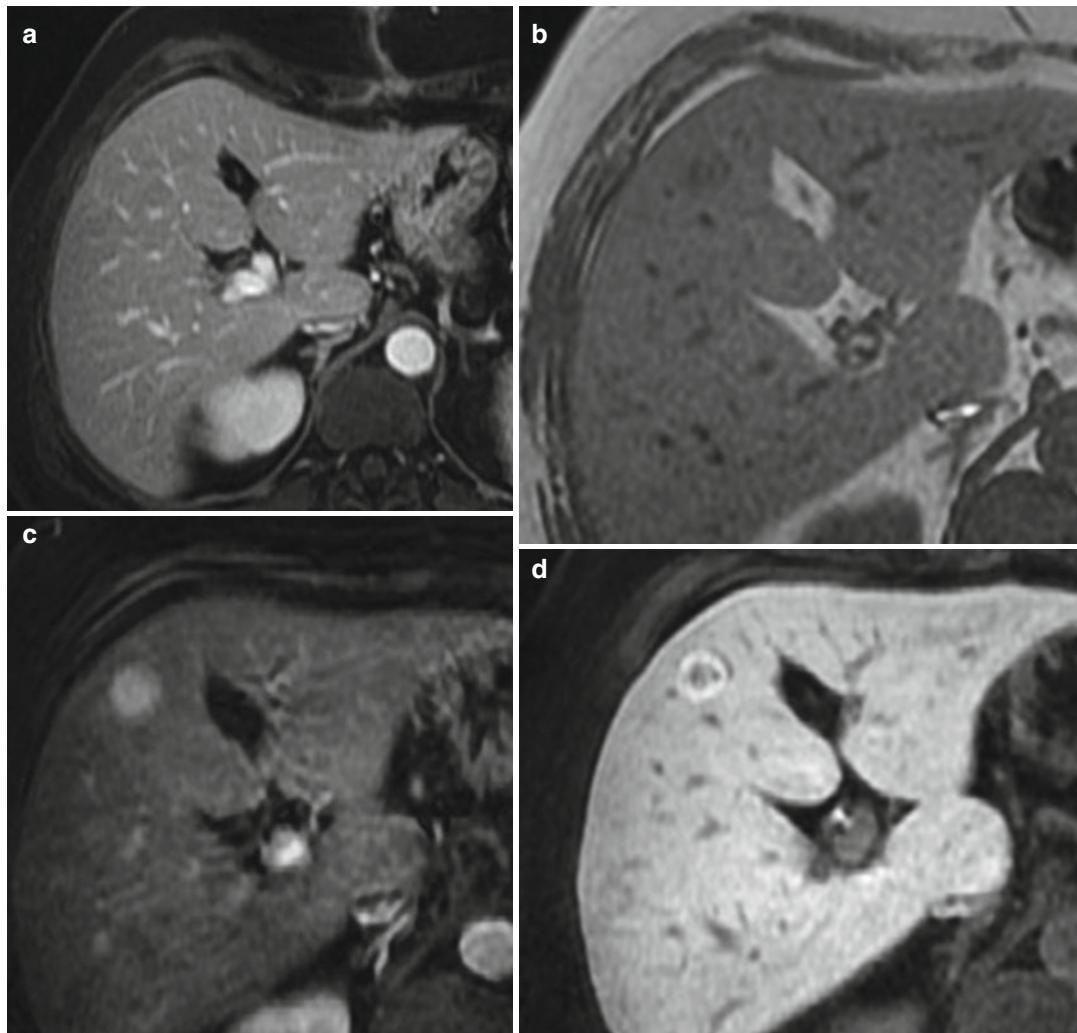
(a-d) FNH. MR images pre- and posttreatment with a hepatobiliary contrast agent (Gd-EOB-DTPA). Pretreatment T1-weighted MR image post-gadolinium injection showing no lesion (a) and 6 years later a lesion that is slightly hypointense on posttreatment T1-weighted MR image (b), posttreatment T1-weighted MR image post-gadolinium during the hepatic arterial phase showing
